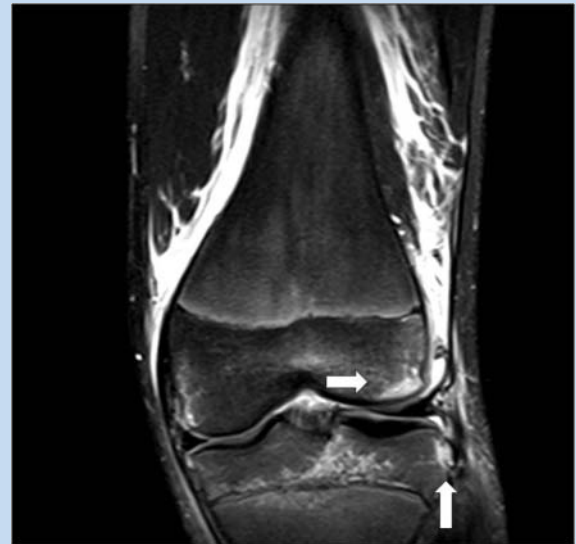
Coronal T2 turbo spin echo magnetic resonance image demonstrates lateral femoral condyle impaction fracture (horizontal arrow) and Segond fracture (vertical arrow).
